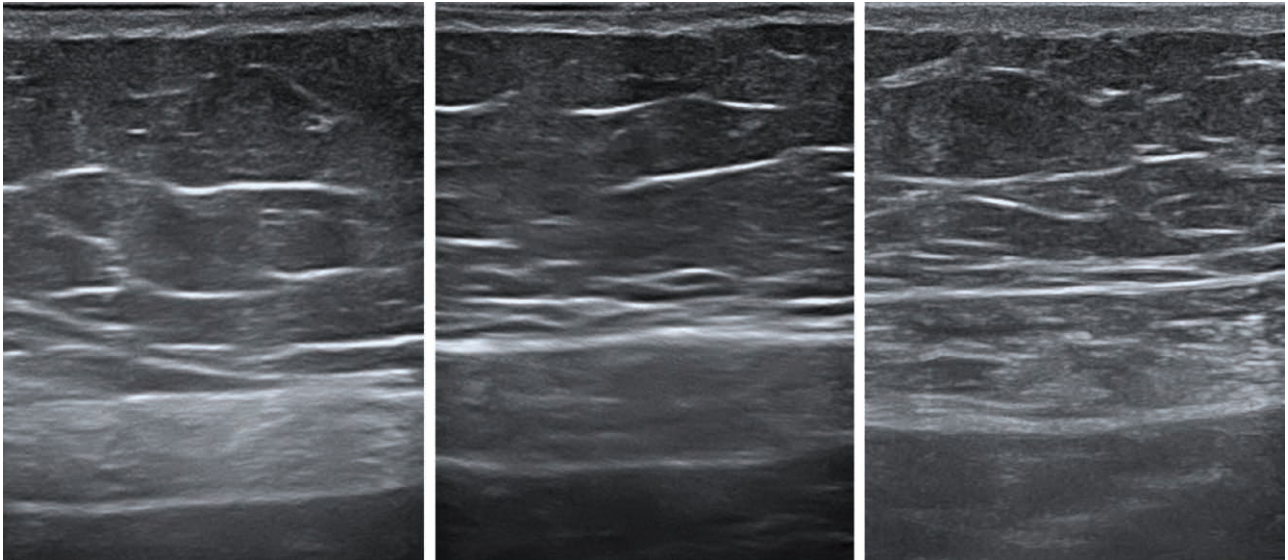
Ultrasound images of a patient from the active group taken at baseline (*left*), 1 month after treatment (*center*), and 6 months after treatment (*right*). The images are showing continuously reducing fat layer with increasing thickness of rectus abdominis.
